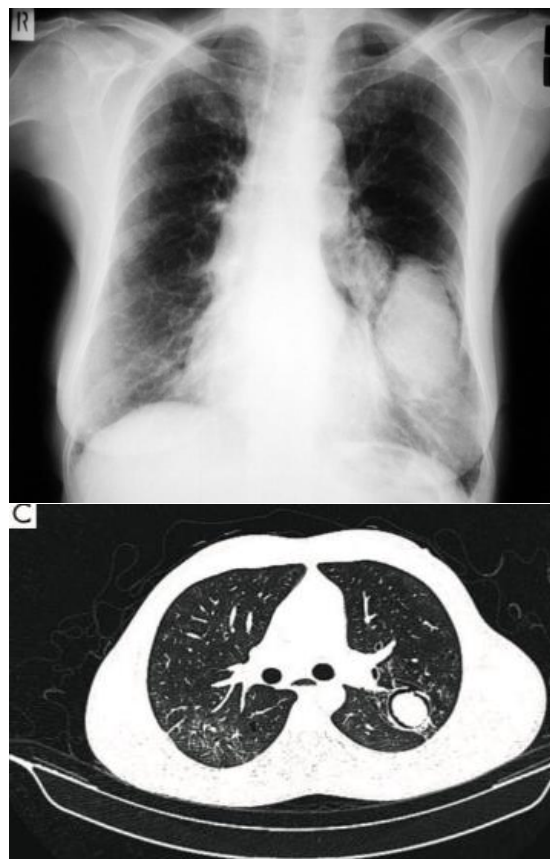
Results of thorax photo and thorax CT scan (Soedarsono and Widoretno, 2019)
